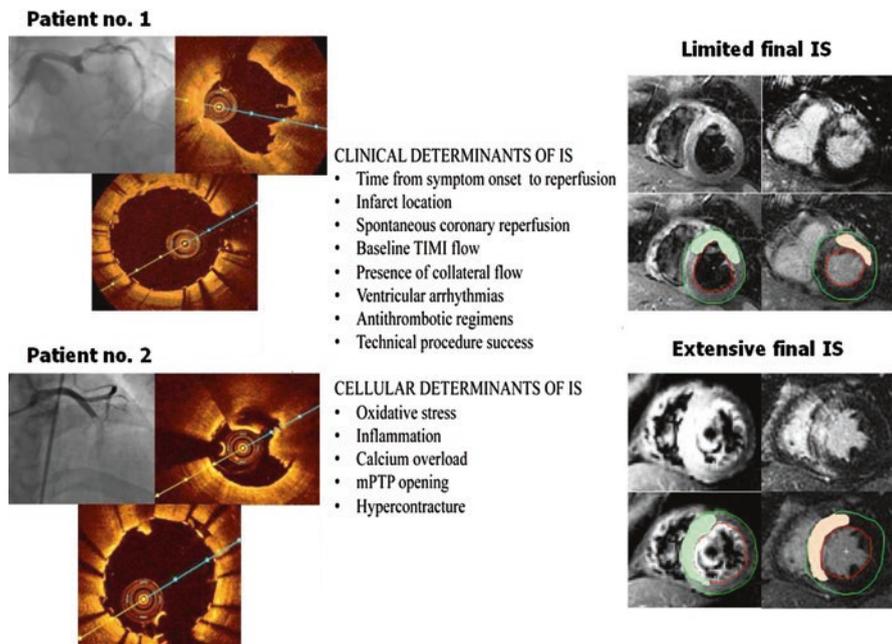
Clinical and cellular determinants of final IS. On the *left*, the angiographic and optical coherence imaging (before and after stent implantation) of two STEMI patients successfully treated with mechanical reperfusion. Cardiac magnetic resonance imaging (on the *right*) reveals the corresponding areas at risk (similar between patients) and the final infarct size (different). *IS* infarct size, *TIMI* thrombolysis in myocardial infarction, *mPTP* mitochondrial permeability transition pore
